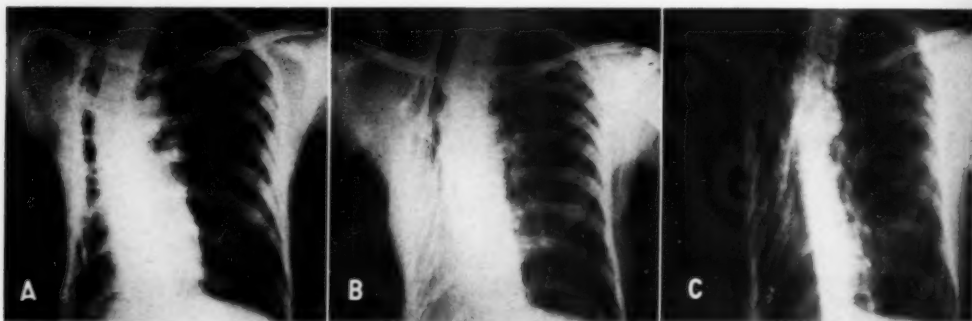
A. Roentgenogram in slight oblique projection showing extensive collapse of lung. Failure to correct position of patient gives an erroneous picture of the degree of collapse; sputum intermittently positive. B. Roentgenogram of same patient taken in corrected position showing "localized lateral convexity" over a probable cavity-bearing area. C. Bucky roentgenogram of same patient showing bone detail and spread of disease to contralateral upper lobe.
